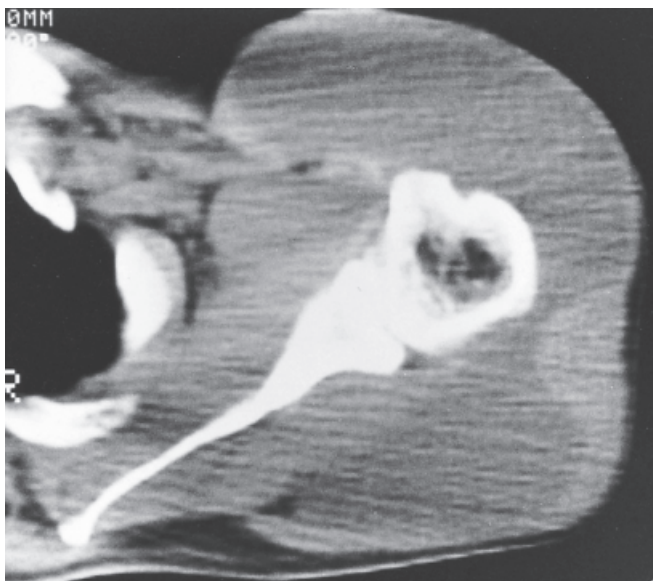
A plain computed tomogram of the swollen shoulder. A large low-density homogenous mass was observed under the deltoid muscle
